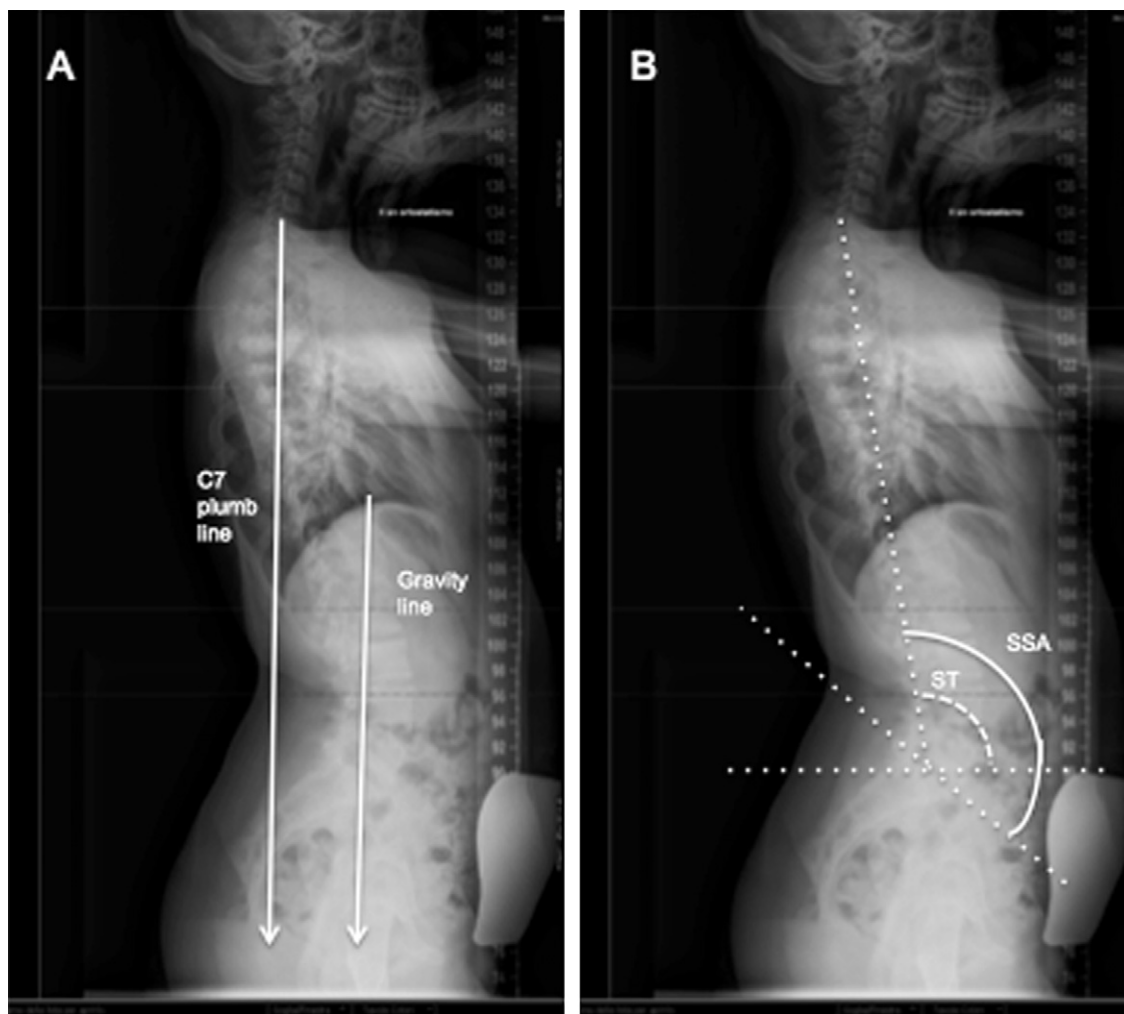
Plain lateral radiographs showing the estimation of global sagittal balance of the spine and pelvis in the standing position. (A) In normal sagittal balance the C7 plumb line will pass behind the femoral heads. (B) The spinosacral angle (SSA) and spinal tilt (ST) may also be used as an overall measure of sagittal balance. When sagittal balance is normal, the weight of the body is ergonomically balanced through the spinal column and the pelvis is over the hips (head of the femurs).
